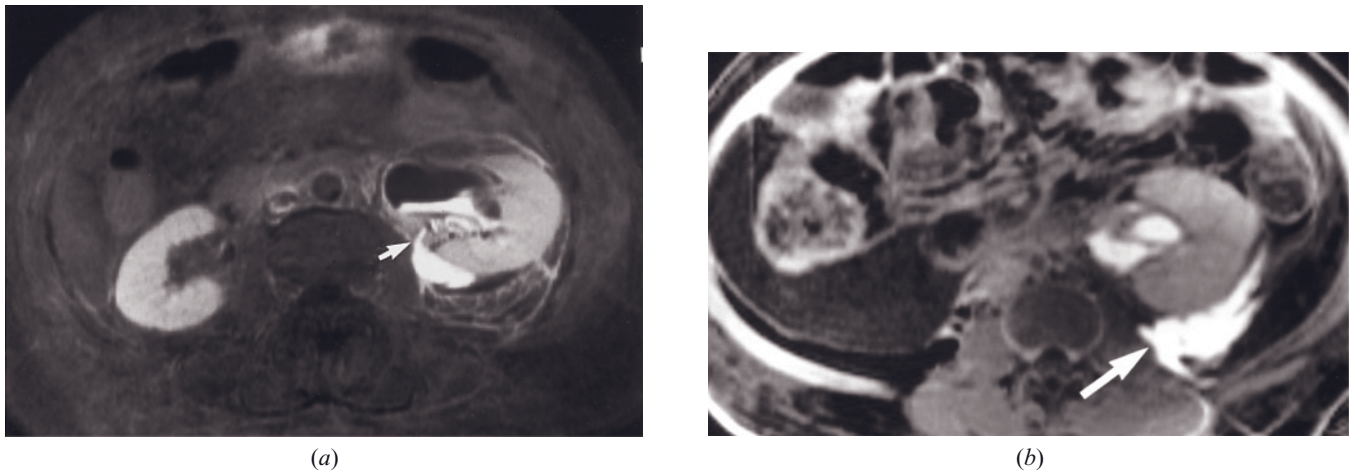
Pyelosinus rupture. T1-weighted late-phase fat suppressed gadolinium-enhanced SE image (*a*) demonstrates leakage of dilute, high-signal-intensity gadolinium (arrow) from a dilated, obstructed left renal collecting system. T1-weighted 3-min fat-suppressed postgadolinium SGE image (*b*) in a second patient with a history of trauma. High-signal fluid extravasates into the perinephric space (arrow, *b*) at the same time as high-signal fluid appears in the collecting system.
